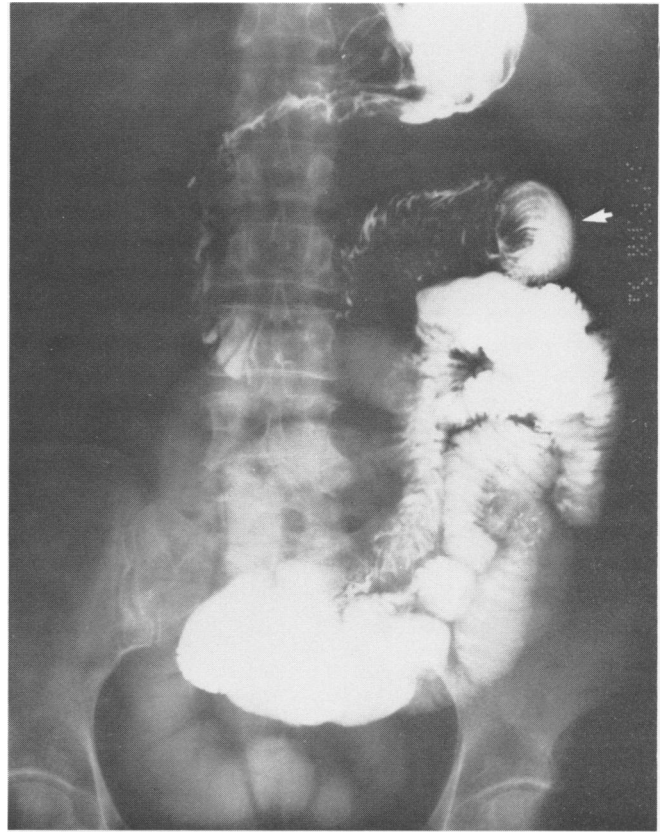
Small bowel x-ray demonstrates jejunal intussusception and characteristic "coiled spring" appearance (arrow).
